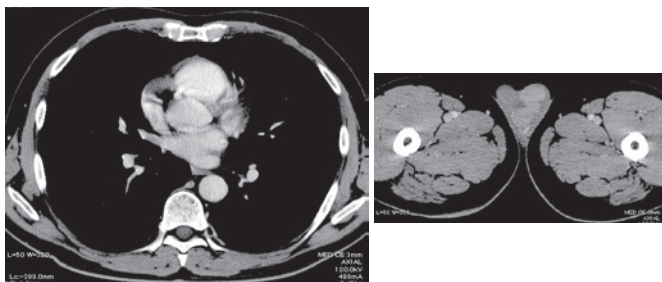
Chest and abdominal computed tomography (CT) showed the left testicular tumor with the radiographic features of malignancy. There was no evidence of cardiac metastasis in the right atrium.
